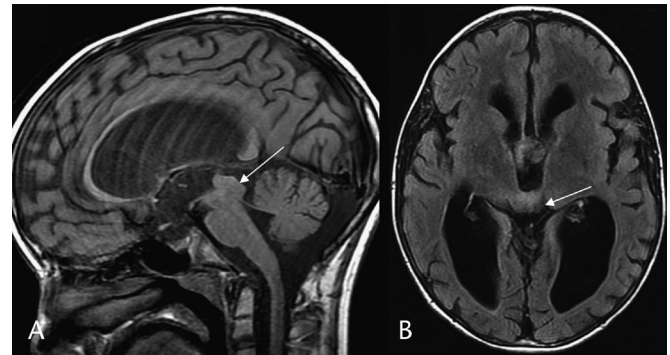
Tectal glioma. Sagittal T1 image (A) shows third and lateral ventriculomegaly with a tectal mass (white arrow) and aqueductal narrowing. Axial FLAIR image (B) shows the hyperintense tectal mass (white arrow). There was minimal gadolinium enhancement (not shown). Hyperintense FLAIR CSF flow artifact is present in the anterior third ventricle.
